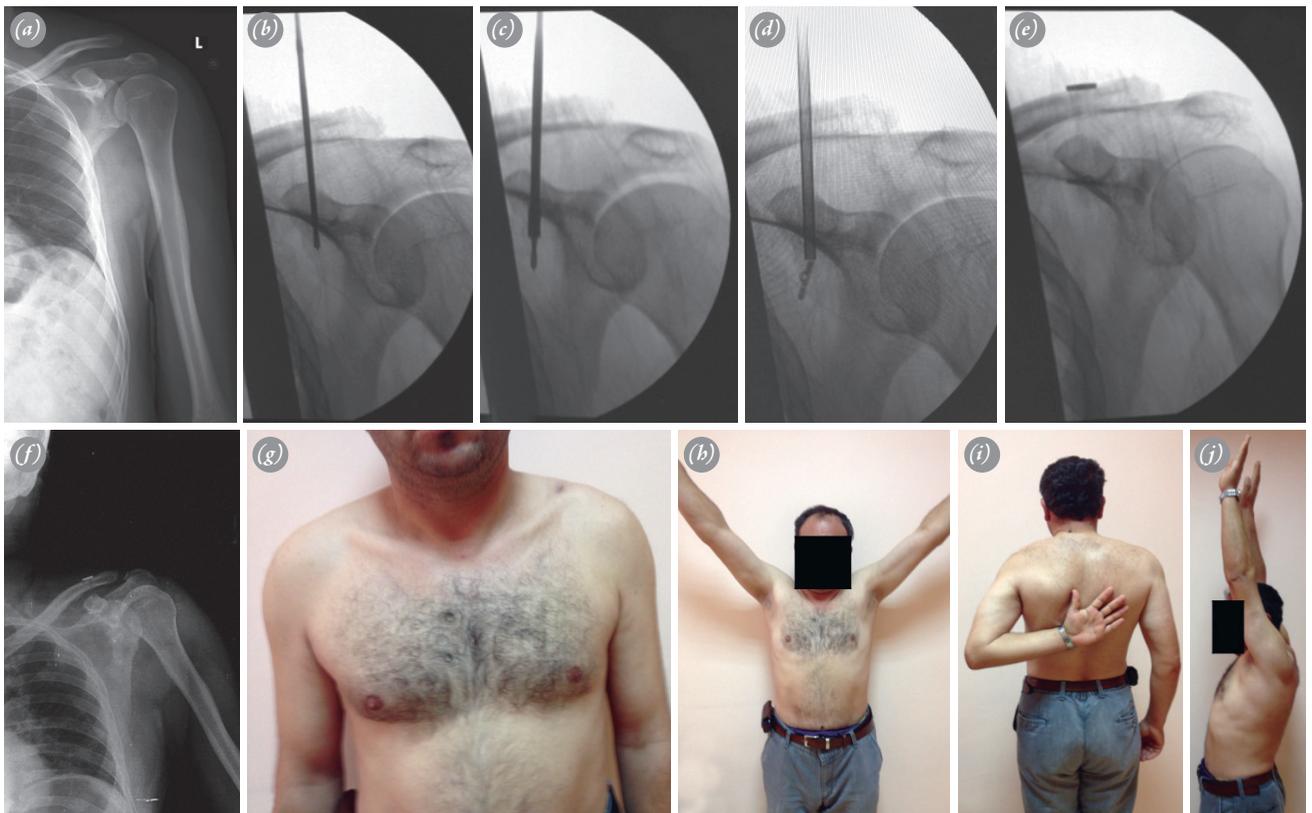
Case no. 9; 42-year-old male MVA Type III AC joint dislocation preoperative, intraoperative, and postoperative X-rays (a–f) and final clinical results (g–j). [Color figures can be viewed in the online issue, which is available at www.aott.org.tr]
